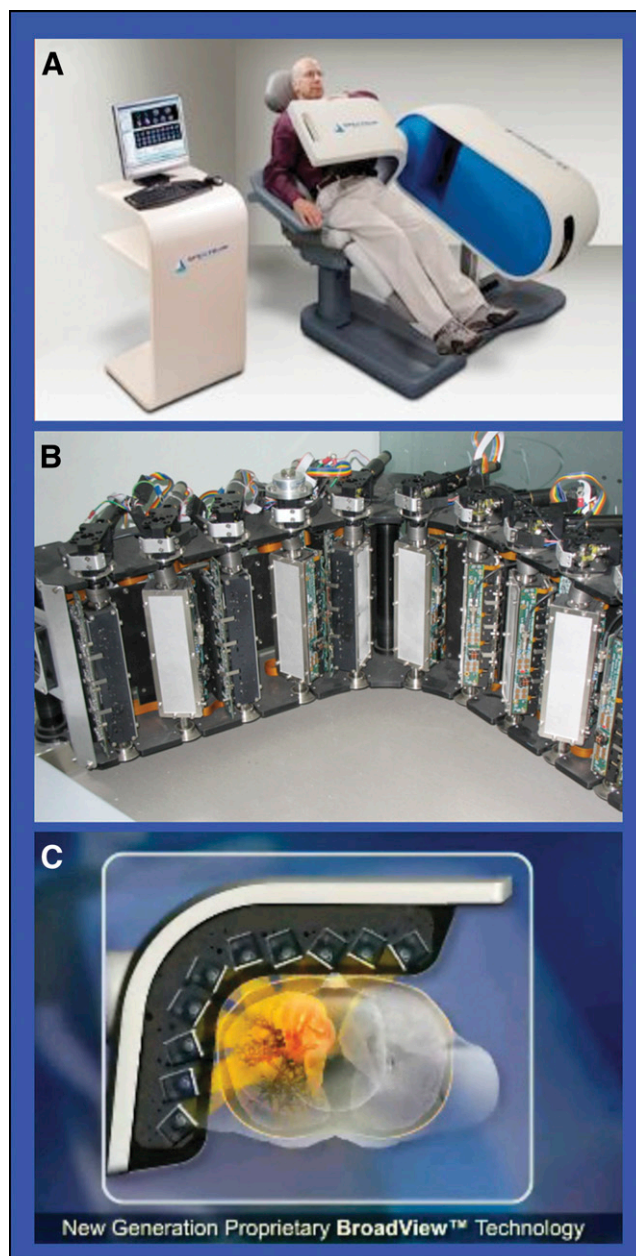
D-SPECT solid state cardiac SPECT scanner (A) and components (B and C).
